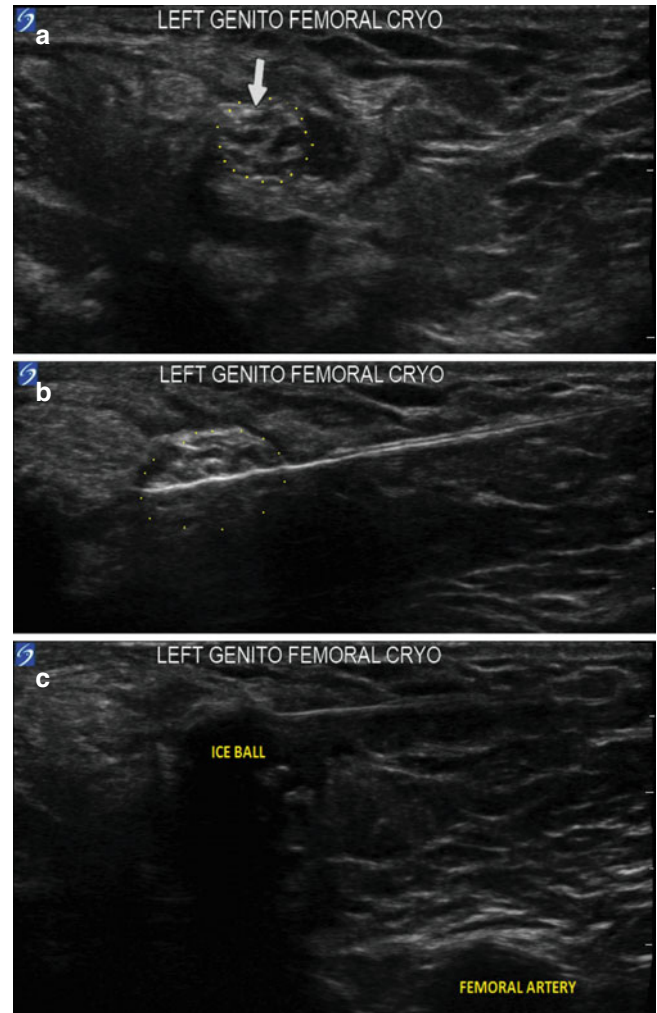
Cryoneuroablation of the genitofemoral nerve at the internal inguinal ring under ultrasound guidance. (a) Ultrasound identification of the internal inguinal ring and the genitofemoral nerve (*white arrow*); (b) cryoprobe placement; (c) cryo-ice ball (Image courtesy of Agnes Stogicza, MD)
